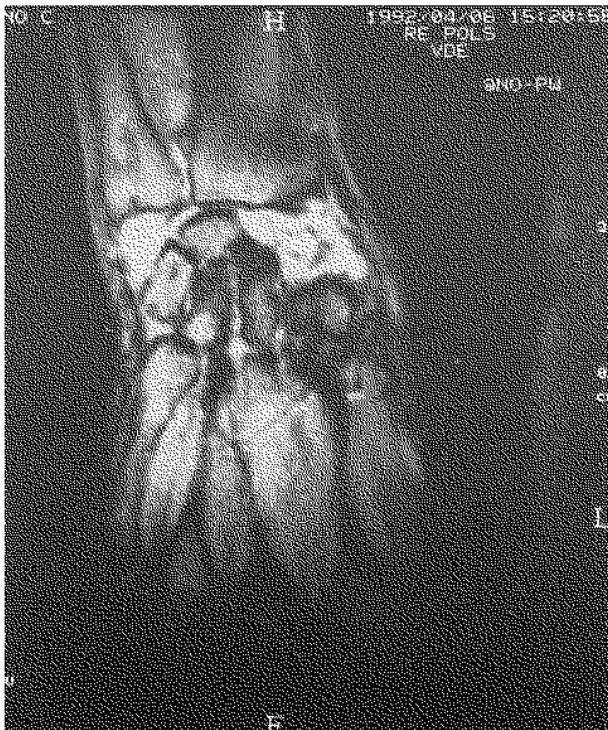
Case 5 MRI aspect.
